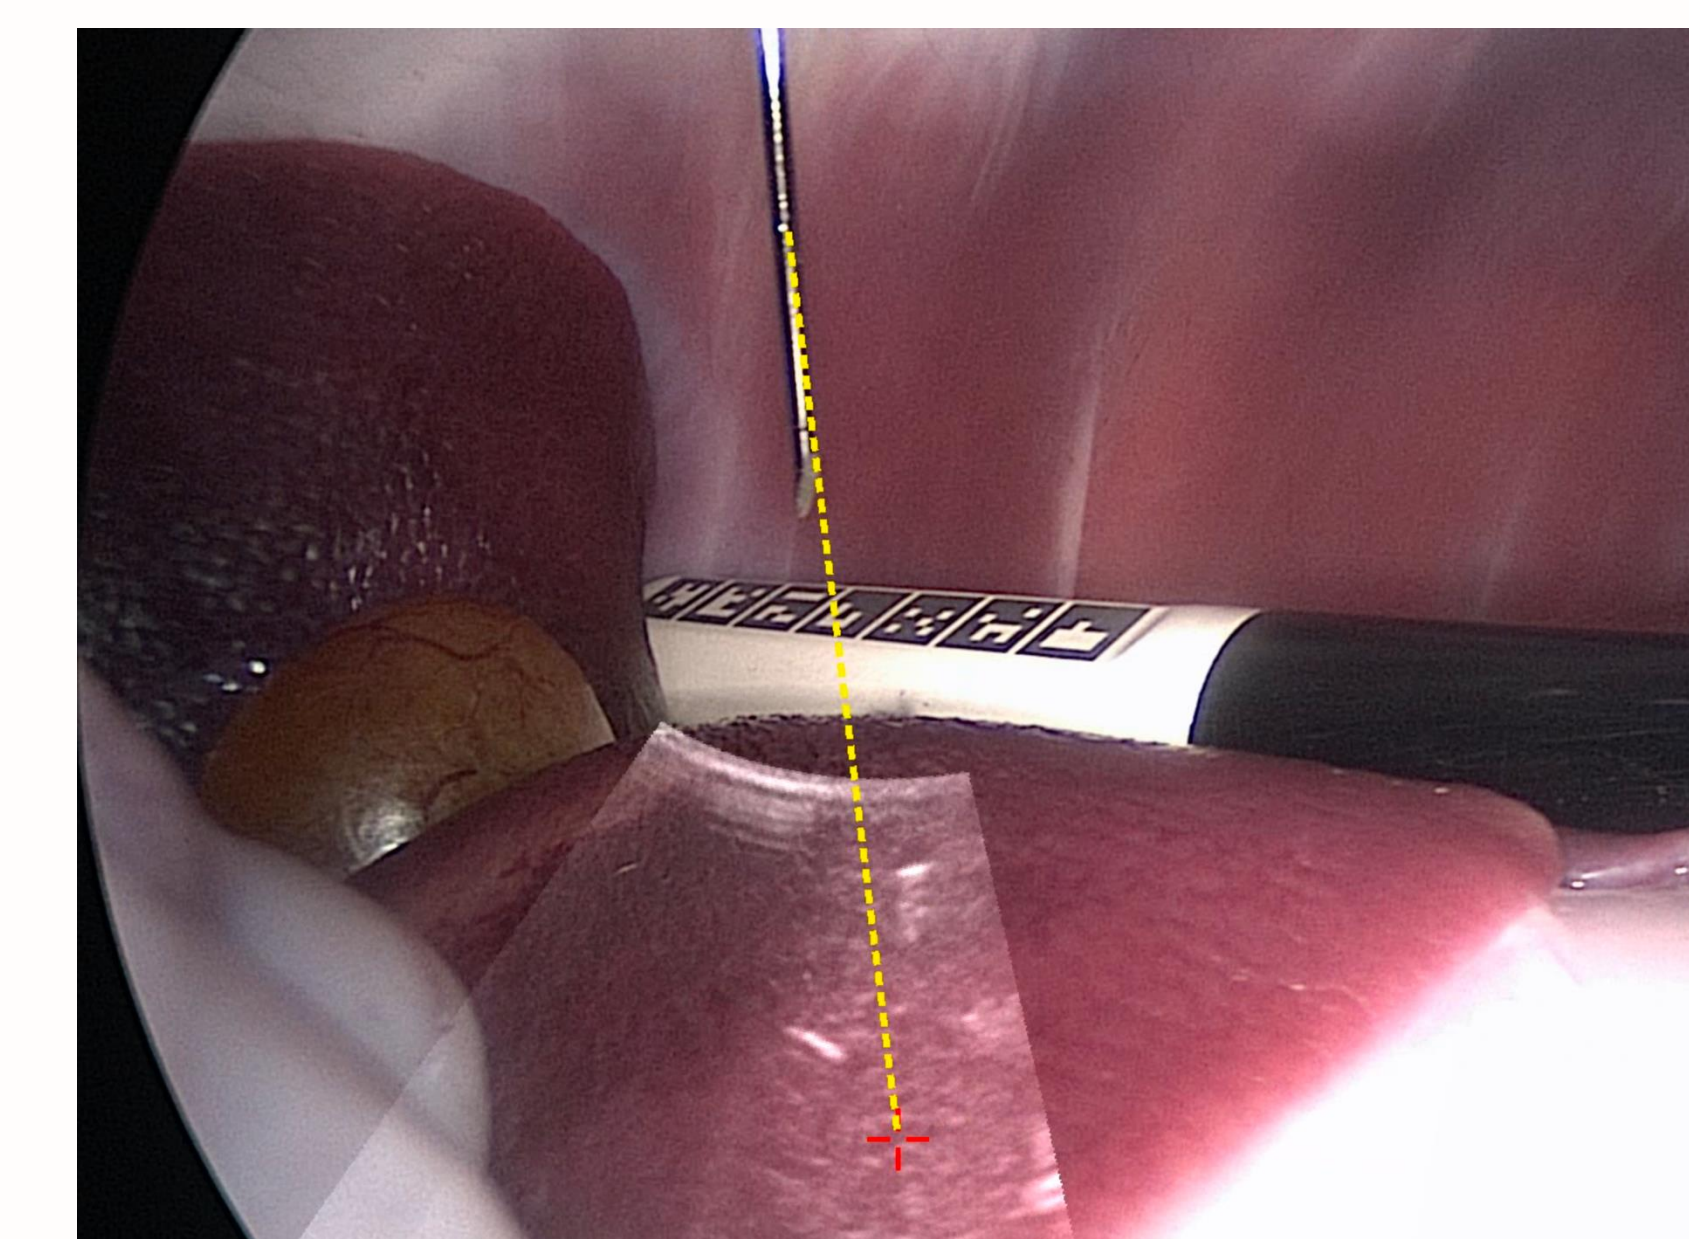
Enhanced needle guidance visualization using the proposed tracked laparoscopic ultrasound probe.
